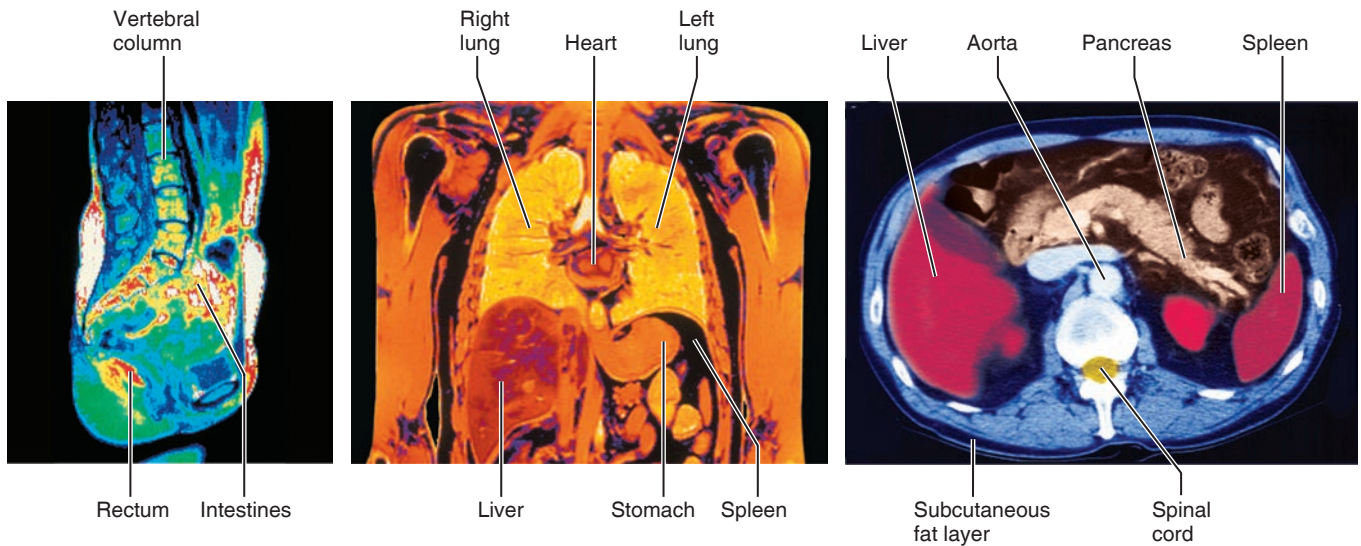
Planes of the body with corresponding magnetic resonance imaging (MRI) scans. Note the transverse section is an inferior view.
